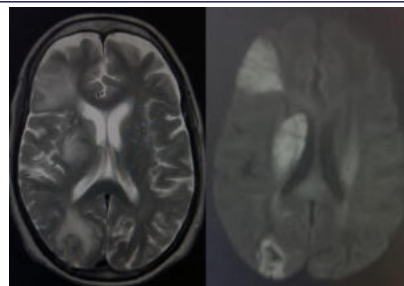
MRI Brain showing acute infarcts in right frontal, parietooccipital and basal ganglia.
